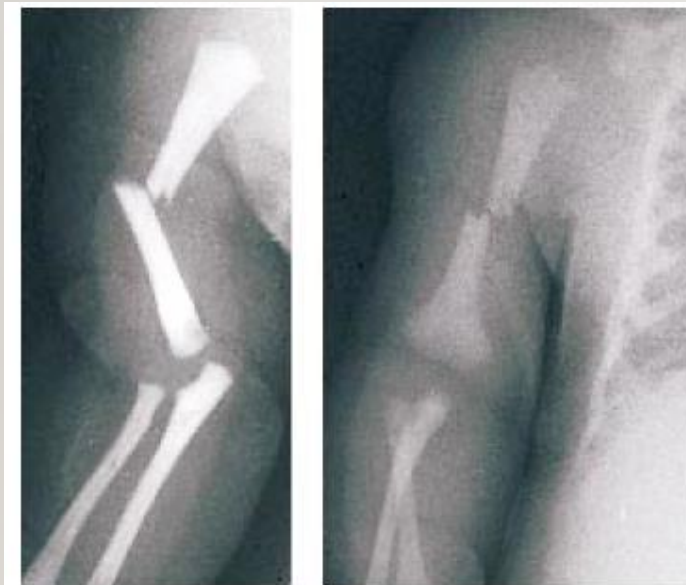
A radiograph of a fracture of the middle third of the right humerus following a difficult delivery. This commonly arises with shoulder dystocia and may be associated with lesions of the brachial plexus due to traction on the shoulder girdle. The upper arm is immobile, painful and may be swollen.
